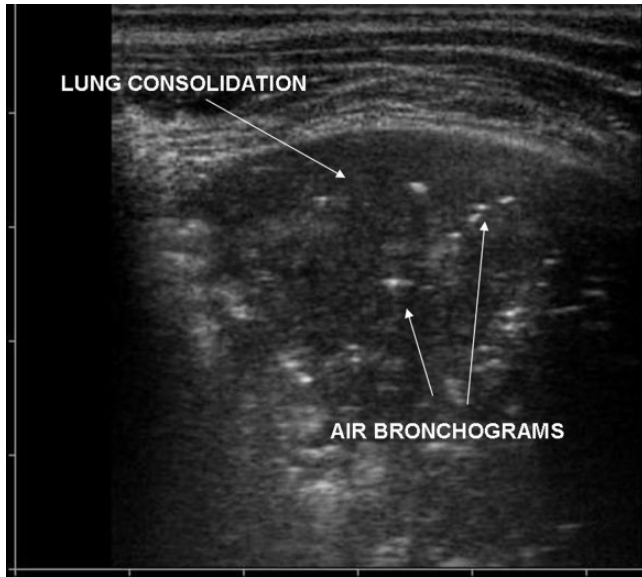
Typical ultrasound image of pneumonia in a paediatric patient with hyperechoic air bronchograms. In real time these would be seen to move together and apart with respiration, indicating that they are arborizing tubular structures. The transition from consolidated to normal lung is typically “shredded” in appearance.
